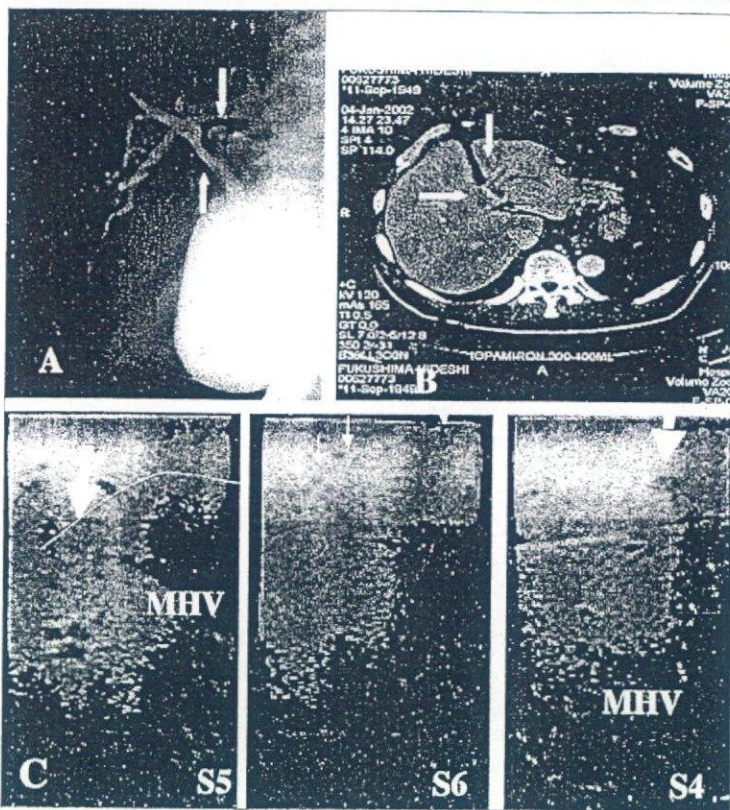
(A) Endoscopic retrograde cholangiopancreatography shows defect of left bile duct. (B) Computed tomography scan shows hilar mass with dilatation of intrahepatic bile ducts in the left lobe. (C) Intraoperative ultrasound shows multiple hypoechoic lesions in the bilateral liver lobes (arrows). MHV: middle hepatic vein.
